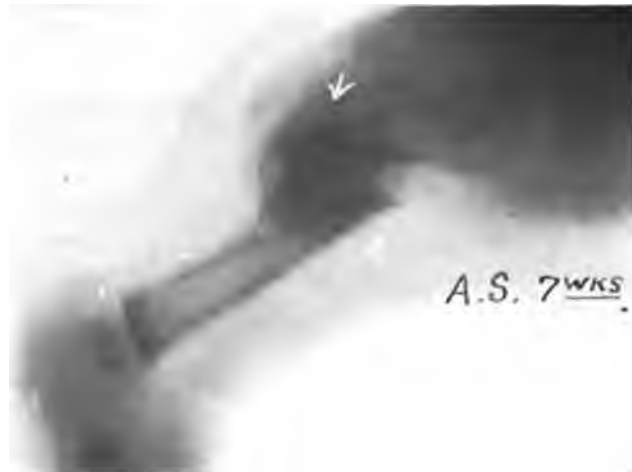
Case 2.* Case of birth fracture of the femur first coming under treatment and roentgenographed at the seventh week. Union was already firm, with the fragments fixed in a position of marked anterior angulation. (Courtesy, Dr. Frank S. Mathews.)
